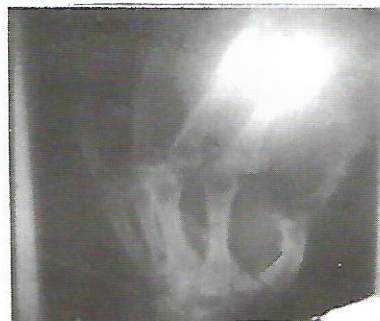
Preoperative x-ray showing severe arthritis of 1<sup>st</sup> CMC joint with subluxation of joint
